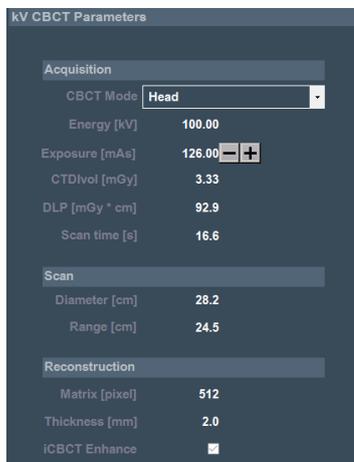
Halcyon Elite kV - iCBCT Enhance parameters for Head and Neck scan acquisition
